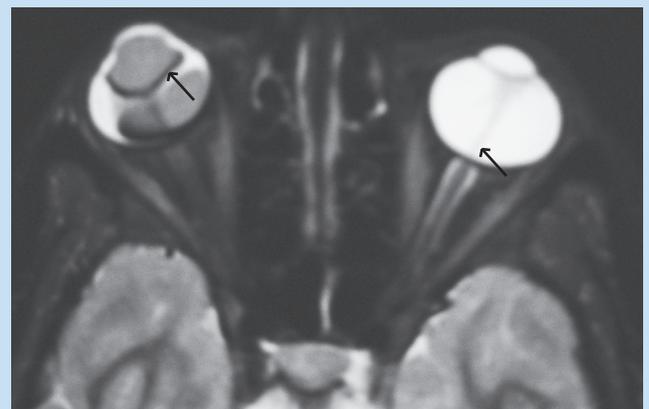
Axial T2-weighted image demonstrates bilateral anterior and posterior PHPV. Left eye: (Posterior PHPV) most of the globe content gives a very high signal that could be due to intraocular haemorrhage accompanying retinal detachment. Note canal of Cloquet (hyaloid canal) connecting the optic disc to the lens. Right eye: the displaced retina appears as a thin black line (arrow). The low signal represents subretinal haematoma that extends to the anterior chamber.
